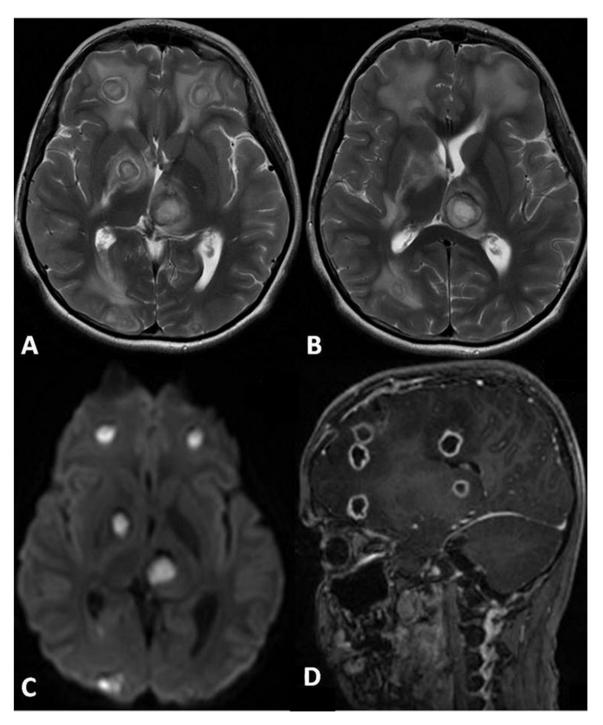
MRI brain: axial T2 weighted (A and B), diffusion weighted (C), and sagittal contrast-enhanced T1 weighted (D) images demonstrate multiple ring-enhancing lesions in both cerebral hemispheres and left thalamus showing central diffusion restriction and moderate perilesional edema suggestive of pyogenic abscesses.
